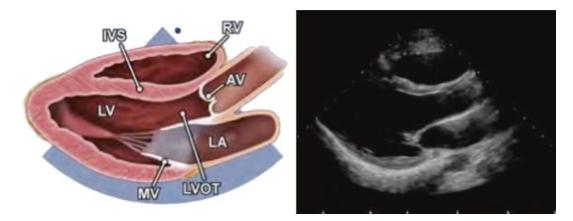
Parasternal long axis. (Reprinted from Mitchell et al. [11]. With permission from Elsevier)
